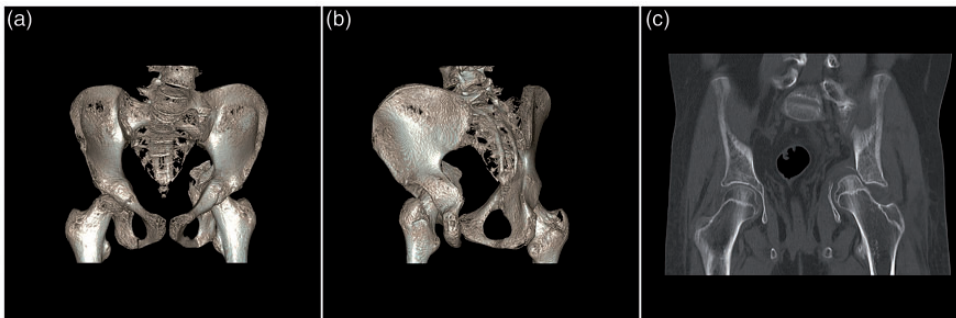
(a) Computed tomography (CT) three-dimensional reconstruction of the quadrilateral plate fracture with no involvement of the anterior acetabular column and wall. (b) CT three-dimensional reconstruction of the quadrilateral plate fracture with no involvement of the posterior acetabular column and wall. (c) CT three-dimensional reconstruction of the quadrilateral plate fracture with dislocation of the femoral head.
